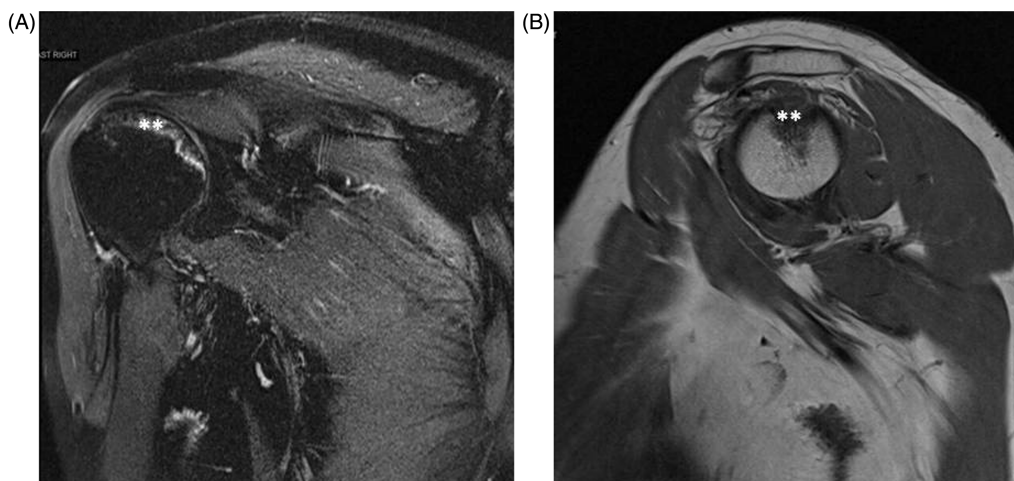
MRI showing region of avascular necrosis of humeral head (refers to location in depiction). (A) Coronal and (B) axial.
